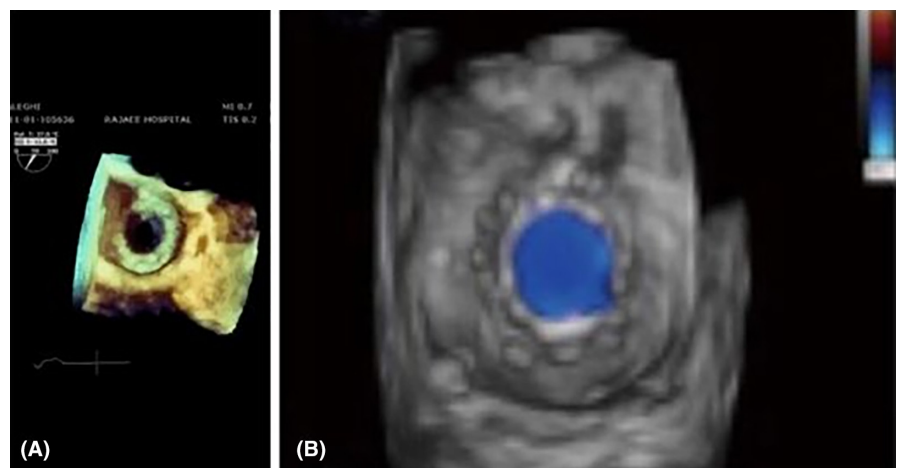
(A, B) Three-dimensional echocardiography showed fully opened leaflets postoperatively.
